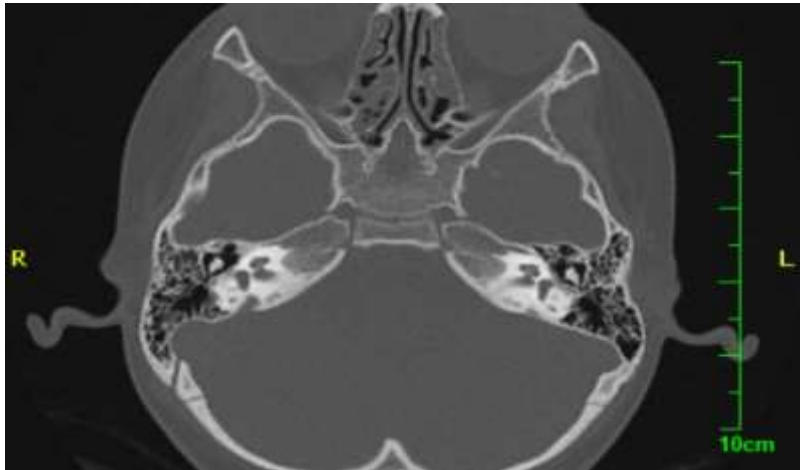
Computed tomography image of Case4. The right ear has an enlarged vestibular aqueduct, while left ear does not.
